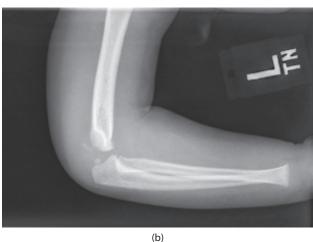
(a, b) AP and lateral elbow x-rays of a 13-month-old infant reveal a transphyseal distal humerus fracture. Critical evaluation of the x-rays reveals the elbow is not dislocated as the distal humerus and radio-ulnar joint are well aligned; however, the capitellum (and unossified distal humerus) are displaced medial to the humerus.
